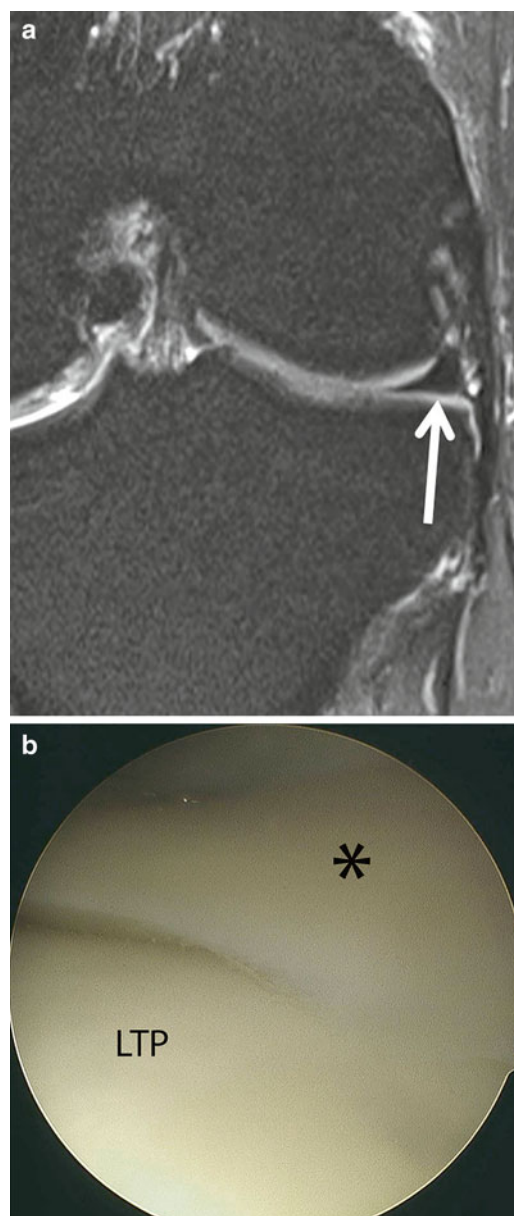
(a) Coronal T2-weighted MRI imaging showing the body of the lateral meniscus. (b) Arthroscopy allows for evaluation of the lateral compartment articular surfaces and the meniscus
